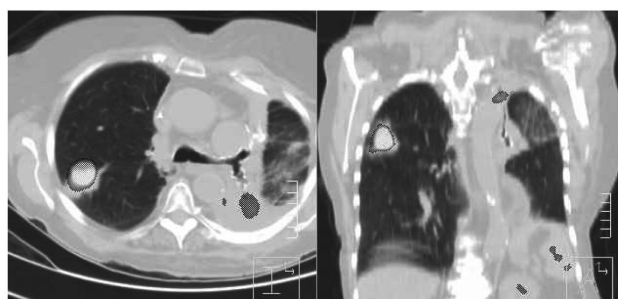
An Example of PET-CT Fusion for the Lung Lesion. Bright Area Contoured With a Black Line is High Signal Region in PET Imaging
